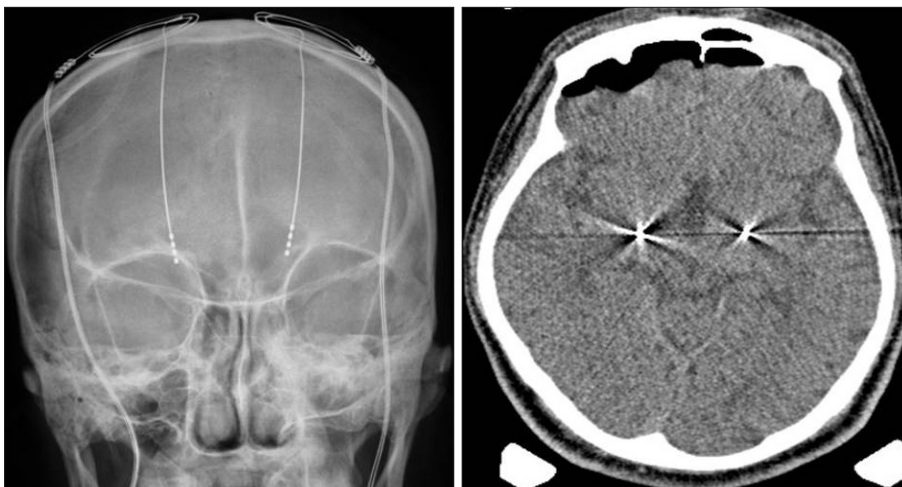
Plain skull X-ray and CT scan showing a deep brain stimulation electrode located on the globus pallidus bilaterally.
